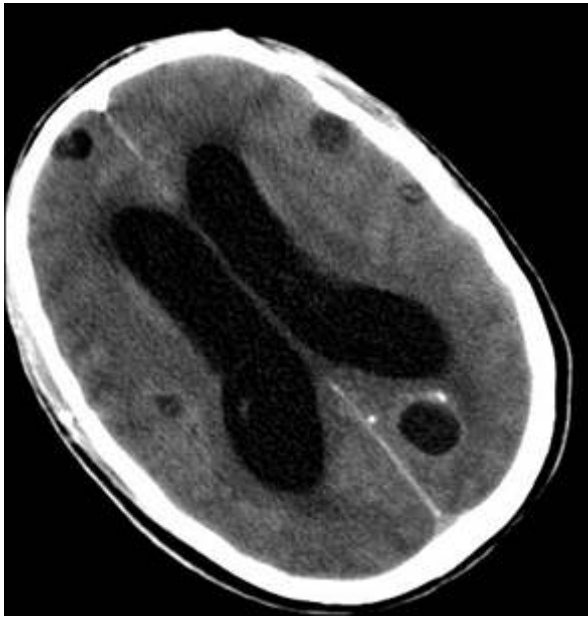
Brain CT scan showing abnormally dilated lateral ventricles (Hydrocephalus) with multiple bilateral cystic lesions
